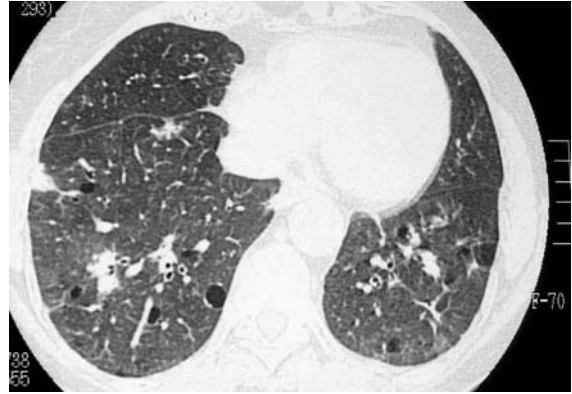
A 62-year-old woman with Sjögren's syndrome. HRCT scan shows a bilateral thin-walled cystic lesions in a random distribution. Multiple ill-defined pulmonary nodules representing MALT lymphoma are visible. Note extensive areas of ground-glass opacity in the lower lung zones.
